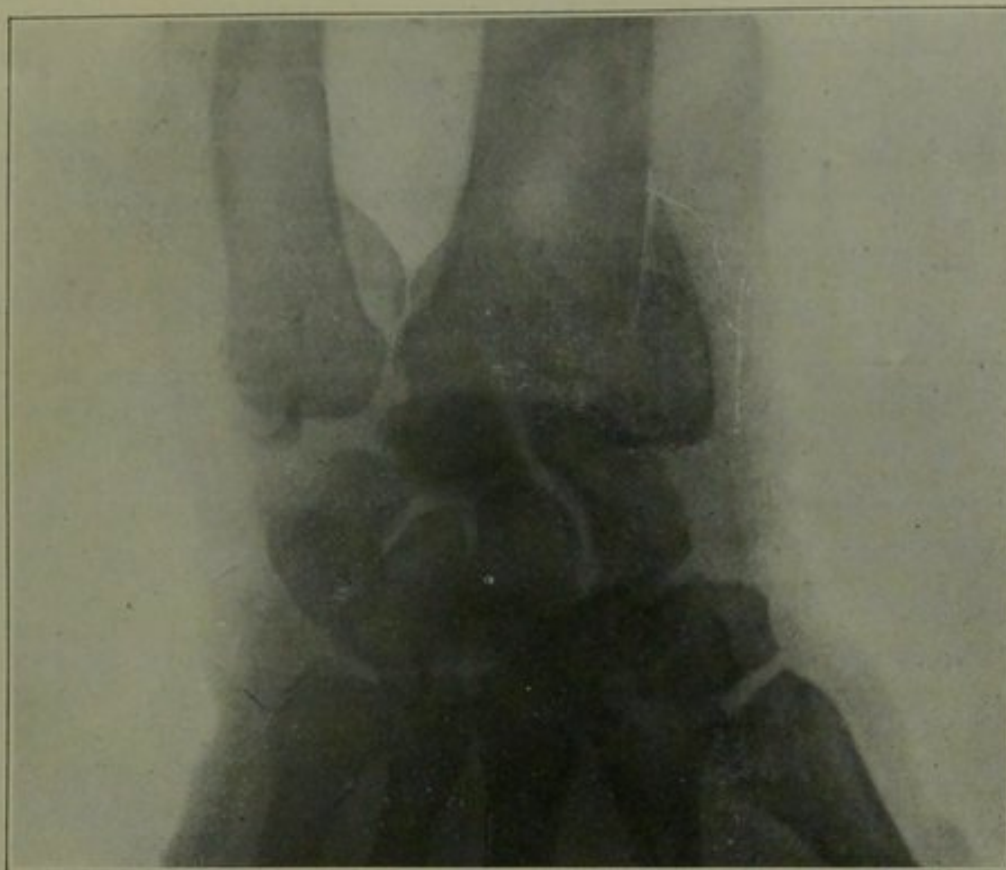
Longitudinal fracture of lower end of radius. Ligaments intact. Undiagnosable except by means of the X-ray.
